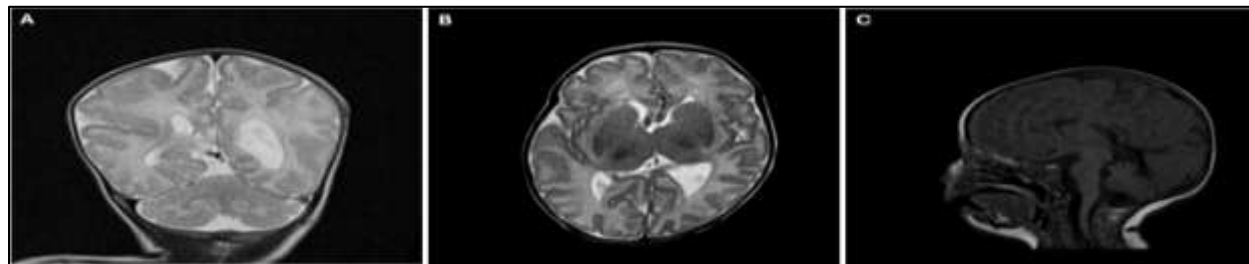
Brain MRI findings A: Coronal T2-weighted image demonstrating a mildly simplified gyral pattern in the right hemisphere, with cortical thickening along the right Sylvian fissure. B: Axial T2-weighted image showing enlarged, rounded basal ganglia with apparent fusion of the caudate nucleus and putamen. The thalami are mildly
